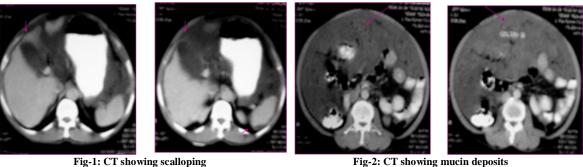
CT showing scalloping
